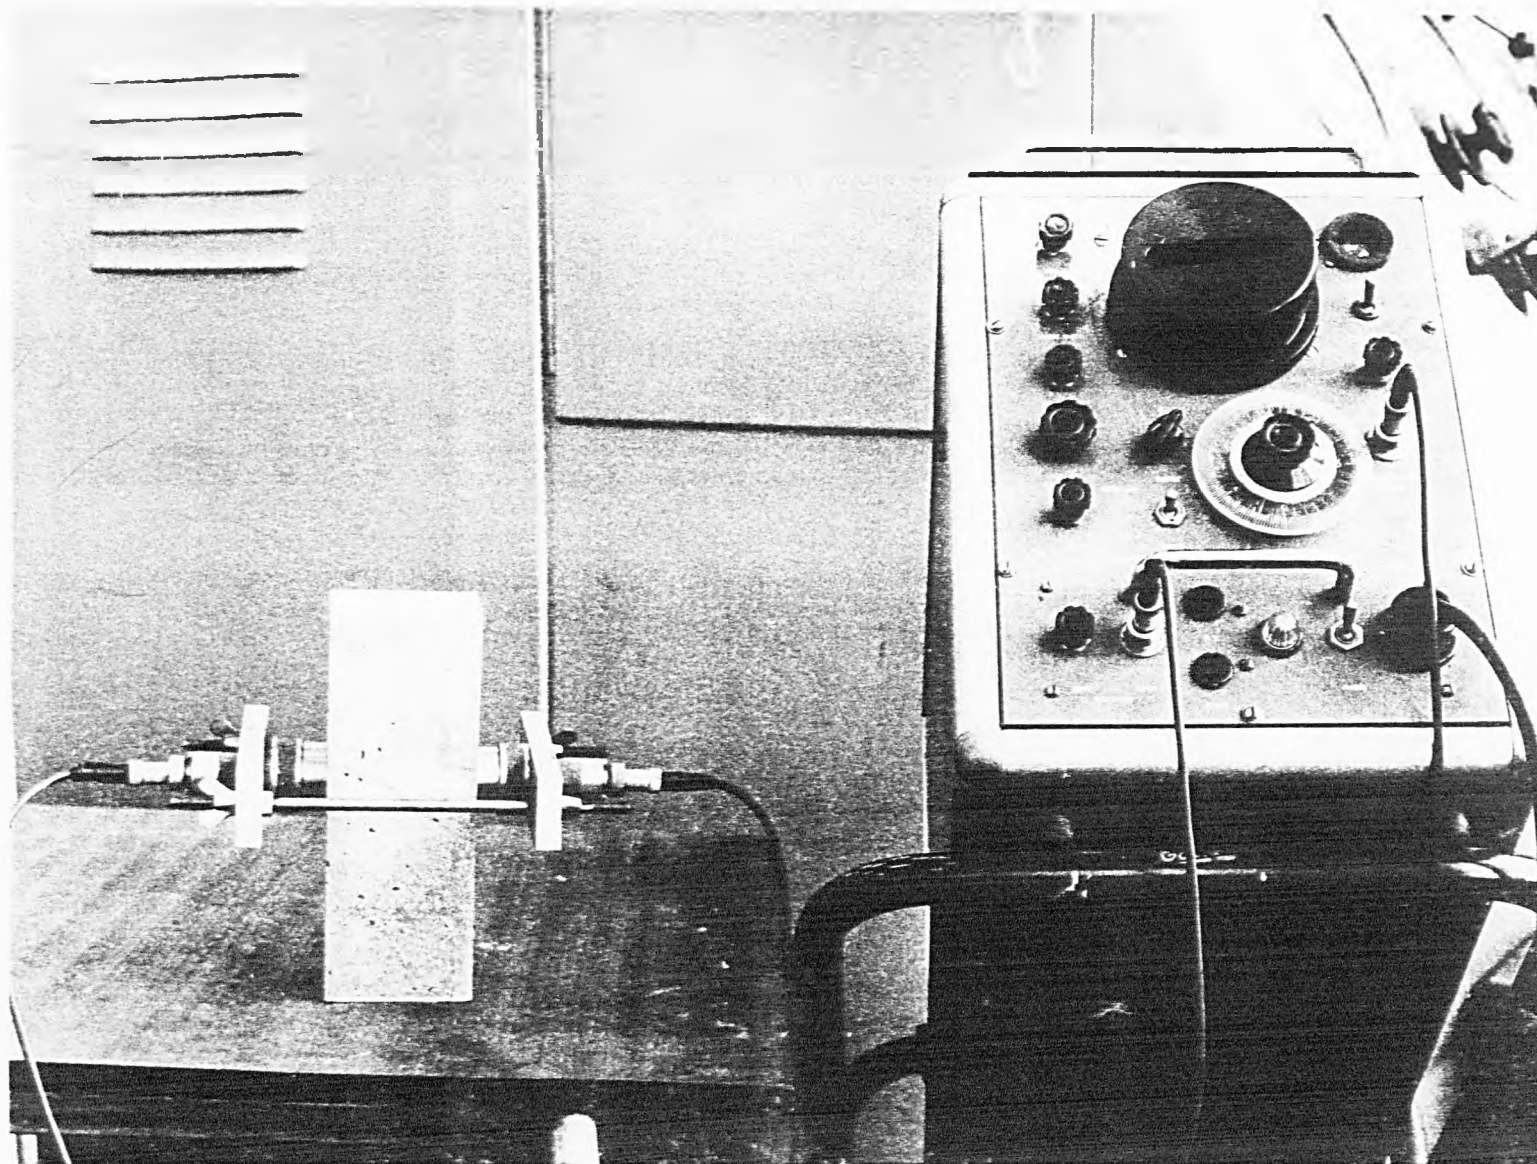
Cawkell Ultrasonic Material Tester
